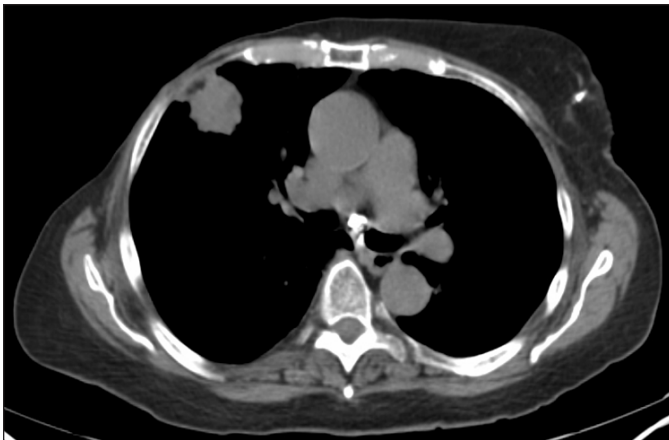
Chest CT demonstrating a 3.2 cm x 2.7 cm spiculated mass in the right upper lobe of the lung.
